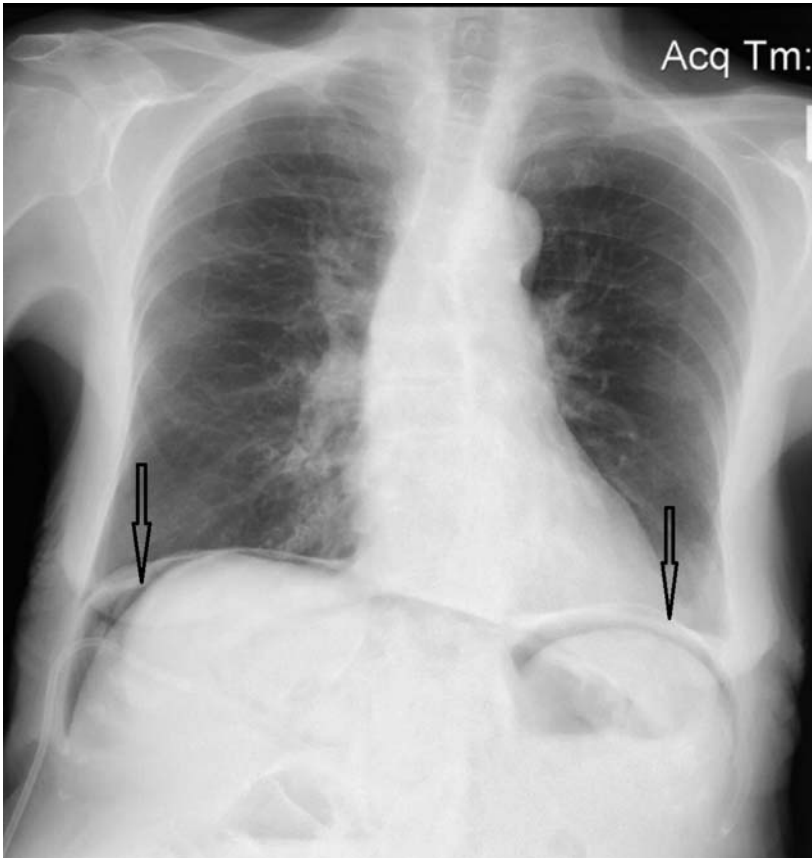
A chest X-ray in case 1 showing pneumoperitoneum (arrows).
